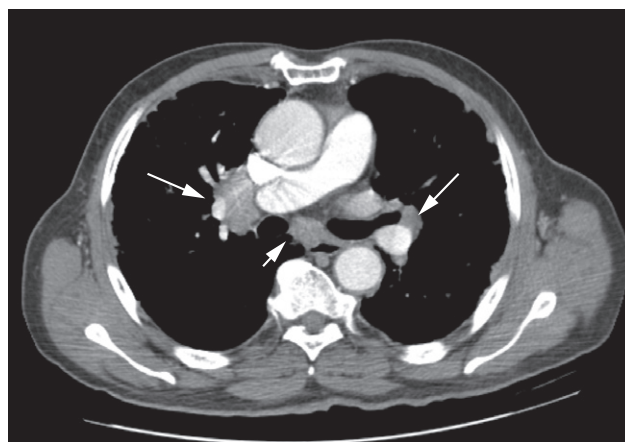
Sarcoidosis. CT scan showing bilateral hilar (long arrows) and subcarinal (short arrow) lymphadenopathy.
